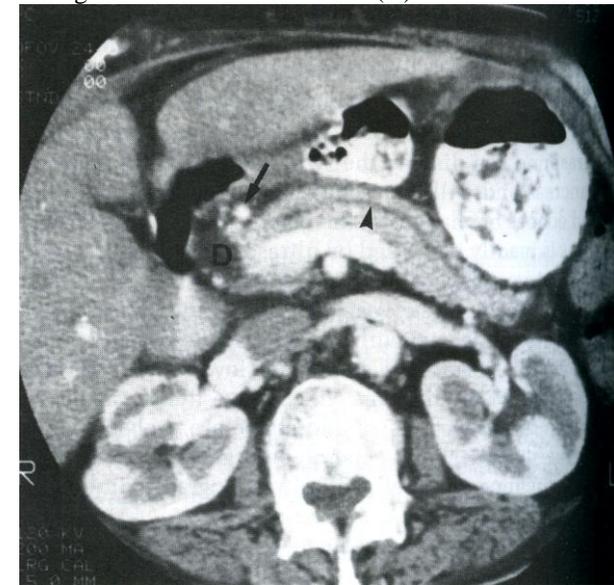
CT of normal pancreas. The normal pancreatic duct (arrowhead) is seen within the pancreatic body. The gastroduodenal artery (arrow) is seen just above and anterior the pancreatic head. (D = bile duct.)
